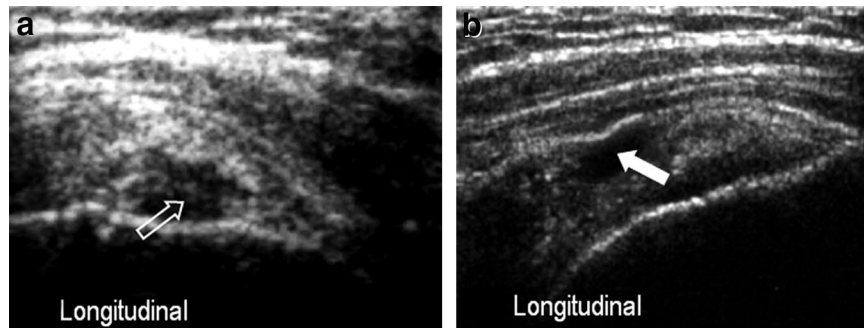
Longitudinal sonogram of partial-thickness tear of the supraspinatus. a, Hypoechoic defect interrupting the articular surface of the tendon (open arrow). b, Hypoechoic defect interrupting the bursal surface of the tendon (arrow).
